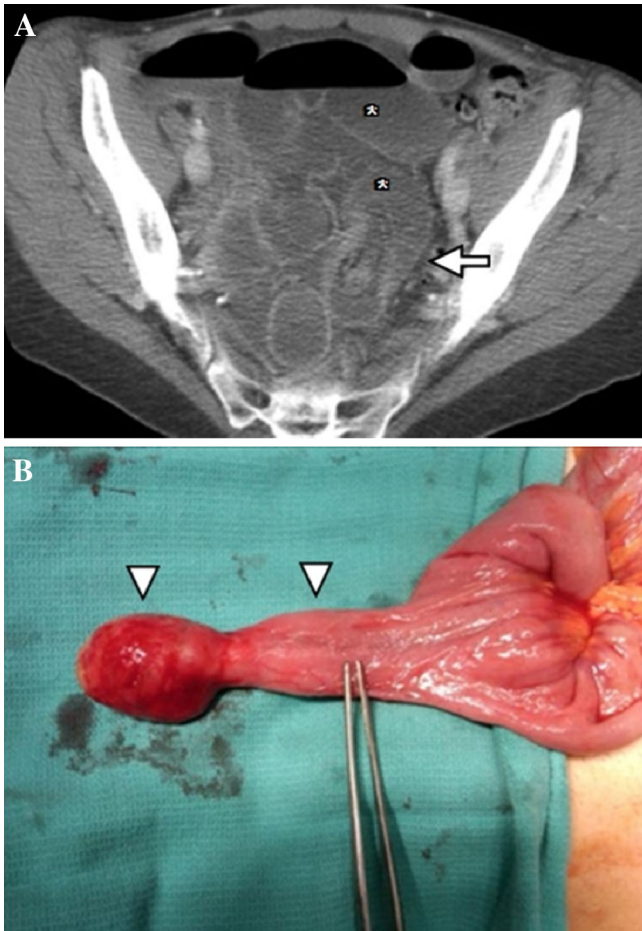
Intussusception and SBO secondary to a Meckel's diverticulum serving as lead point. A Axial contrast-enhanced CT image demonstrates dilated proximal small bowel (asterisks) with single abrupt transition zone at the level of the intussusception (arrow). B Intra-operative image reveals the Meckel's diverticulum (arrowheads) as the cause of the intussusception.
